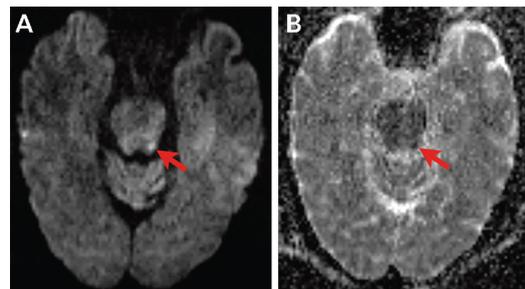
Imaging of the patient in CASE 7-7 with Lhermitte peduncular hallucinosis. Diffusion-weighted imaging (DWI) (A) and apparent diffusion coefficient MRI (B) demonstrated a mesencephalic stroke (arrows), consistent with a diagnosis of peduncular hallucinosis.
